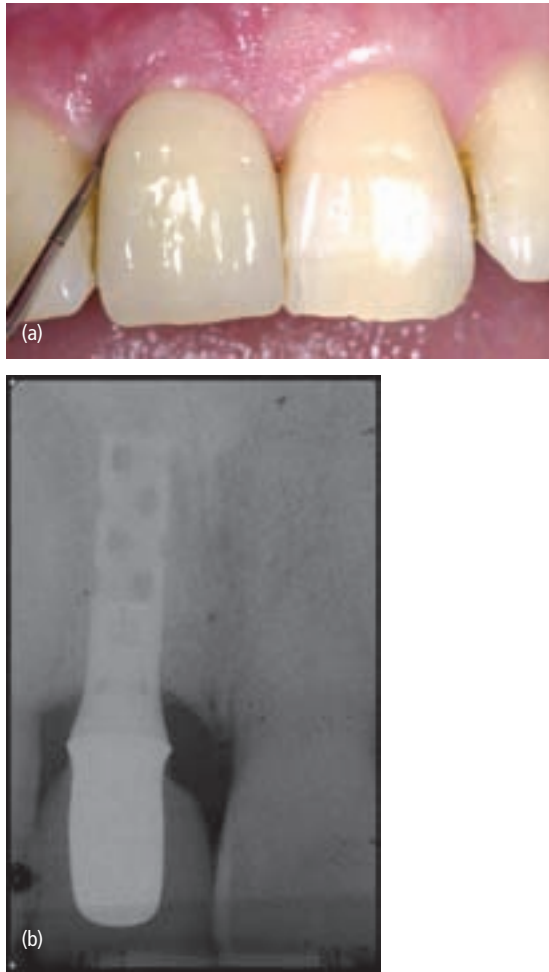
Bleeding on probing (34, 37). (a) Absence of bleeding on probing on light force application indicates peri-implant stability. (b) Radiograph confirming absence of any peri-implant bone loss after 5 years of function.
